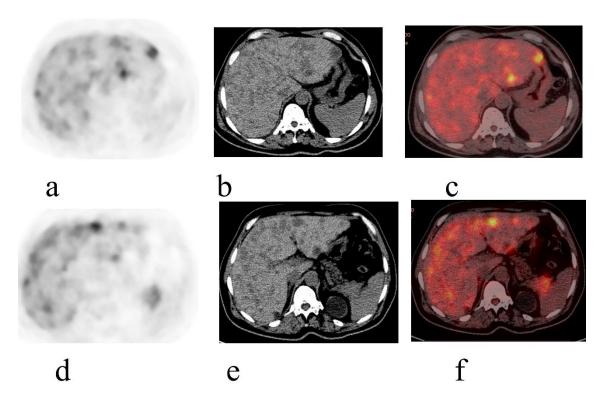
Case 3: axial views: a, b& c images showing multiple FDG avid bilobed hypodense hepatic focal lesions; a PET image, b CT image, c fused image, d, e& f images showing FDG avid mass related to pancreatic tail; d PET image, e CT image, f fused image
